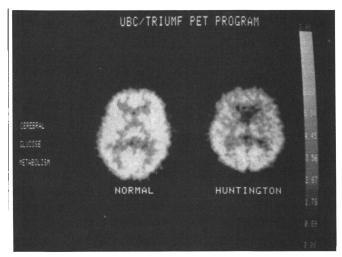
FDG PET scan of a patient with early Huntington's disease, who had normal caudate nuclei as assessed by CT. There is obvious hypometabolism in the caudates compared to a normal scan at the same level, as well as a decrease in cortical metabolism, particularly in the frontal lobes.
